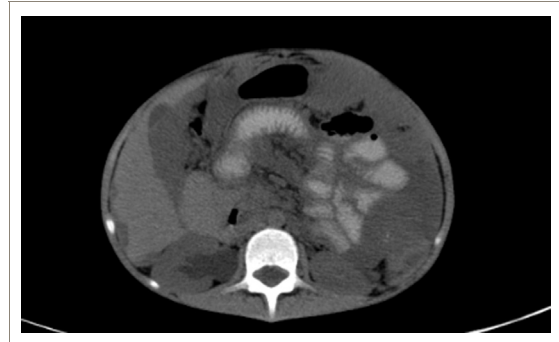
Case 2, CT abdomen.
